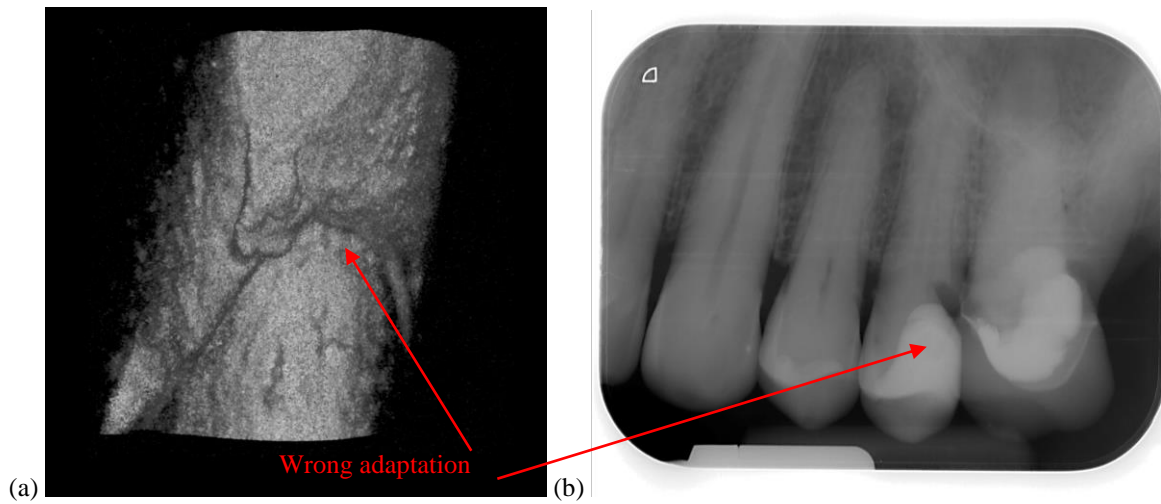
Examples of wrong adaptation: (a) OCT volumetric reconstruction, (b) intraoral radiography.
